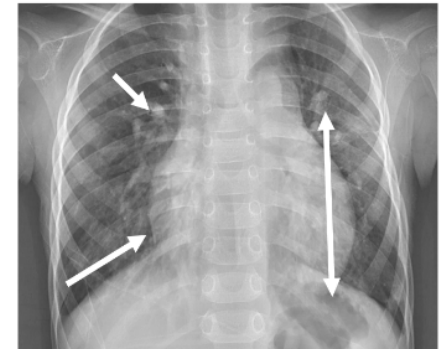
Chest X-ray of the 3 year old boy showing increased broncho-vascular markings (short arrow), blunting of right cardio-phrenic angle (long arrow) and apparent globular shaped heart and cardiomegaly (double ended arrow)
